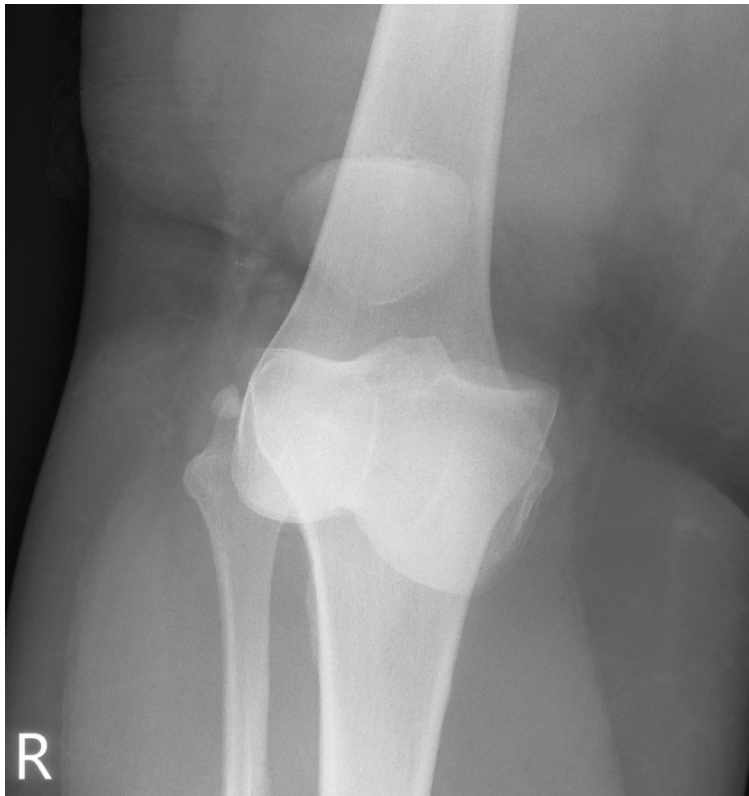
Plain anteroposterior radiograph for an anterior knee dislocation.
